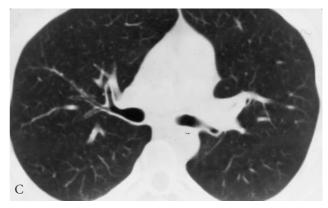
Tracheal bronchus. Computed tomography examination demonstrates a tracheal bronchus (A) arising from the distal trachea just above the carina (B). The normal right upper lobe bronchus is noted (C).
